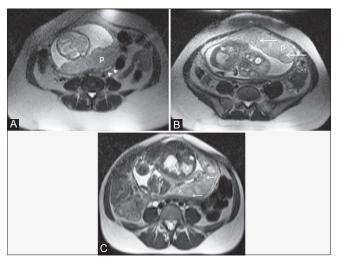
(A-C): Varying MRI appearances of normal placentation at different gestational ages. (A) Axial T2 HASTE MR image shows a homogeneous placenta (p) at 23 weeks of gestational age. (B) Axial T2 HASTE MR image shows a slightly lobulated placenta (p) due to visualization of faint sporadic septi (arrows) at 30 weeks of gestational age. (C) Axial T2 HASTE MR image shows a mildly heterogeneous stratified placenta (p) due to multiple placental septi (arrows) at 37 weeks of gestational age (mature)
